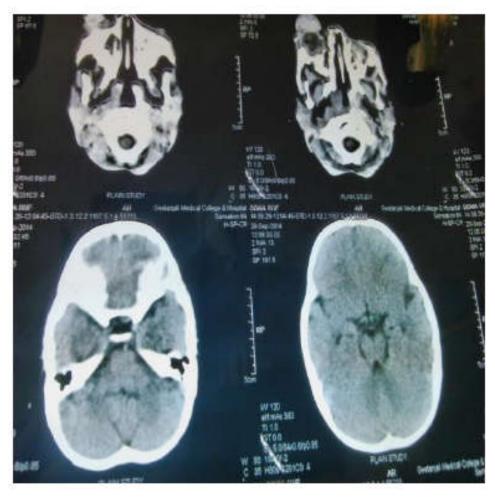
RE CT scan showing Hemangioma displacing the globe
